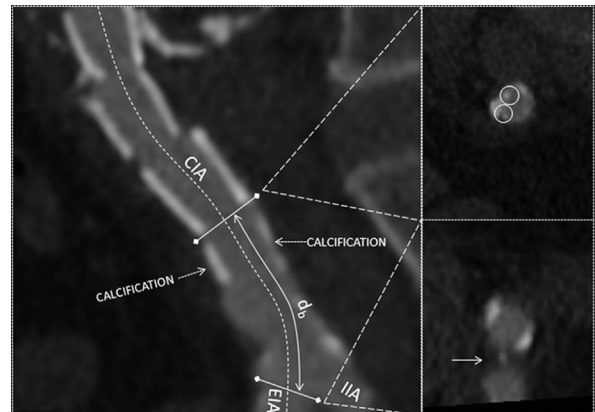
A central luminal line (CLL) computed tomography (CT) measurement (d_b) taken at the distal landing zone on the baseline CT scan. The position of the distal stent graft is recorded relative to the bifurcation of the common iliac artery (CIA). The first oblique axial reformatted image where at least two stents struts were visible was considered indicative of the distal stent position (circles). The first reformatted slice where there was a clear space between the external iliac artery (EIA) and the internal iliac artery (IIA) was considered the level of the iliac bifurcation (arrow). Lines perpendicular to the CLL demonstrate the projection of each oblique reformat and indicate the central point within each reconstructed slice.
